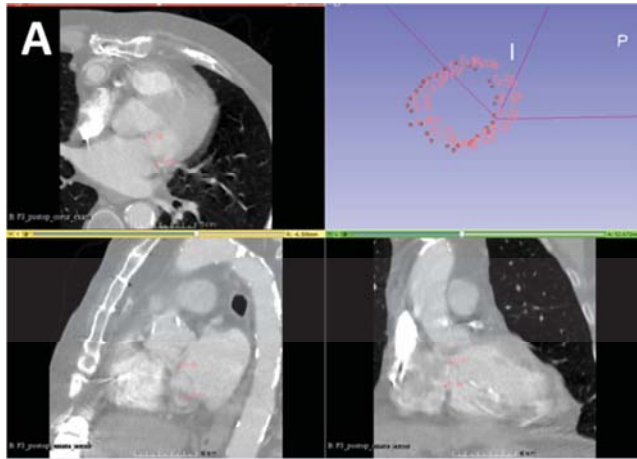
A. Screenshot of a LVAD implantation preoperative planning and postoperative analysis tool: definition of the mitral annulus by the user on post-implantation CT scan. B. Three-dimensional representation of the cardiac chambers after segmentation with the obtained mitral orifice plane. C. Coordinates system for the LVAD apical cannula orientation with respect to the mitral valvular orifice; description through angles θ and φ for quantification of displacement from ideal orientation. IVS: Interventricular Septum.
